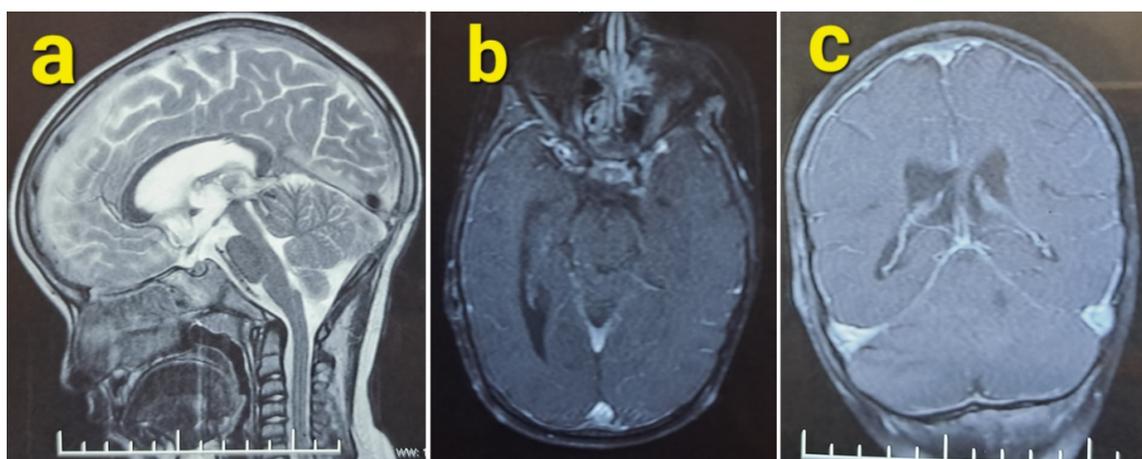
Postoperative MRI scan of pineal tumor excision
